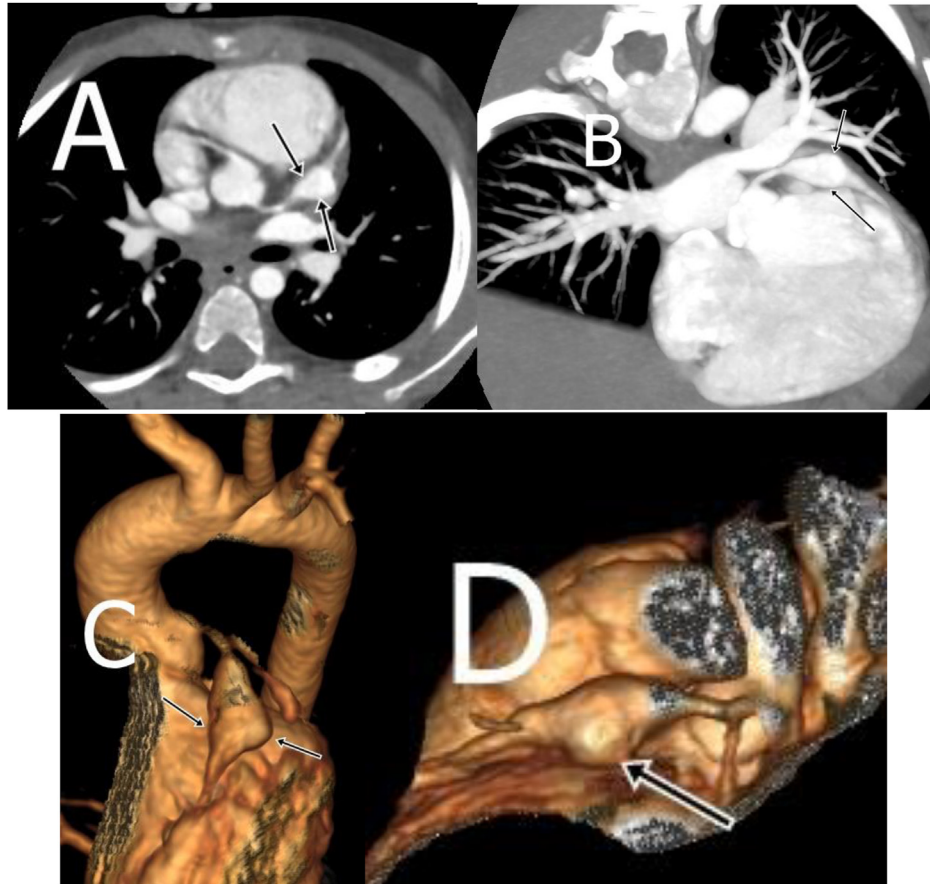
(A) Axial, (B) curved planar reformatting, (C and D) volume rendering cardiac computed tomography angiography images showing fusiform aneurysm of the left anterior descending (arrows).
